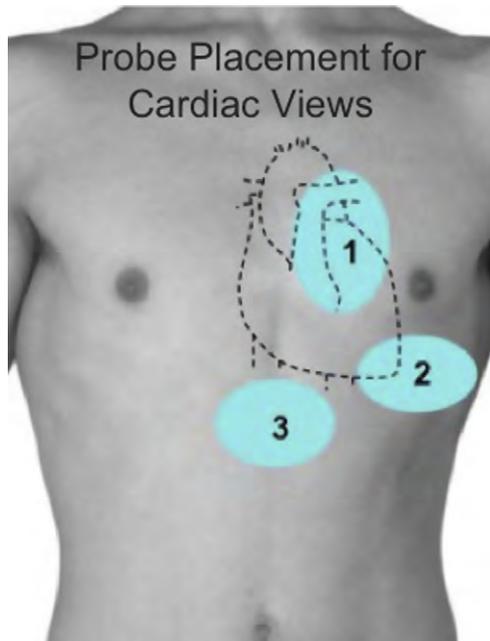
Probe placement for standard cardiac views: (1) parasternal, (2) apical, and (3) subxiphoid.
